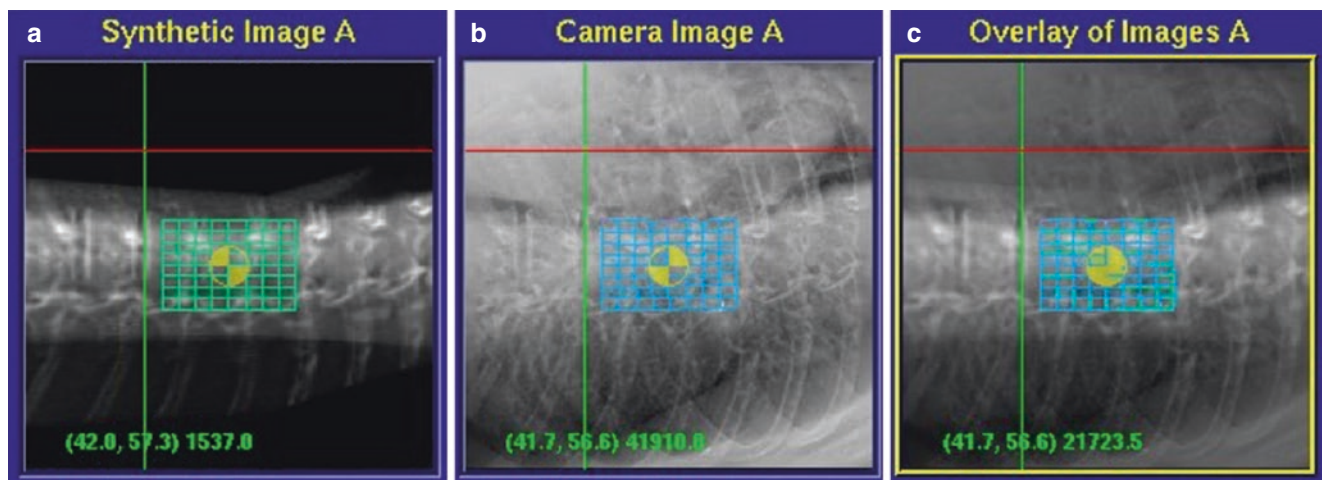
Fiducial-less tracking of the spine by the XSight® (Accuray, Sunnyvale, CA, USA) spine software for intrafraction motion management. In (a), a 9×9 deformable grid, each intersecting point acting as a fiducial, is overlaid onto the digitally reconstructed radiograph (DRR).
